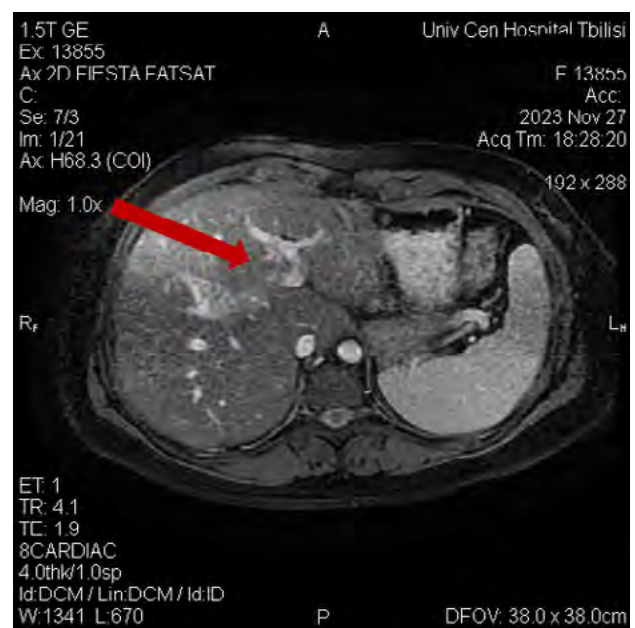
MRI and CT results in one month after reconstructive operation. The pces where anastomosis has been placed is pointed with arrow.
